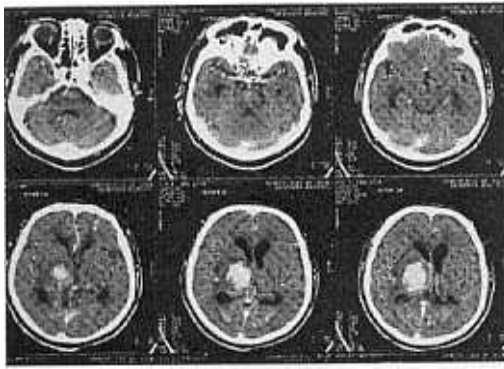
is the actual example of the clinical application of this system. In this case, a patient arrived at the emergency room at midnight. The patient was semicomatose. He showed dense hemiplegia on the left side. The neurosurgery resident examined the patient and ordered a CT brain scan. The CT brain scan showed intracerebral hemorrhage on the thalamic area, so he called the oncall staff of neurosurgery to discuss the treatment plan of this patient. Before calling the oncall staff, he turned on the computer system and scanned the CT images with the scanner. It took about 3 minutes. After confirming the quality of scanned image, he called the oncall staff and described the patient's condition. During that time, the oncall staff prepared his home computer and the modem for data receiving, which took about 2 minutes. Then, the resident transmitted the first image. About six seconds later, the first low resolution image was received at the staff's computer terminal and the second, third, and fourth image were overlapped on the first image respectively.
